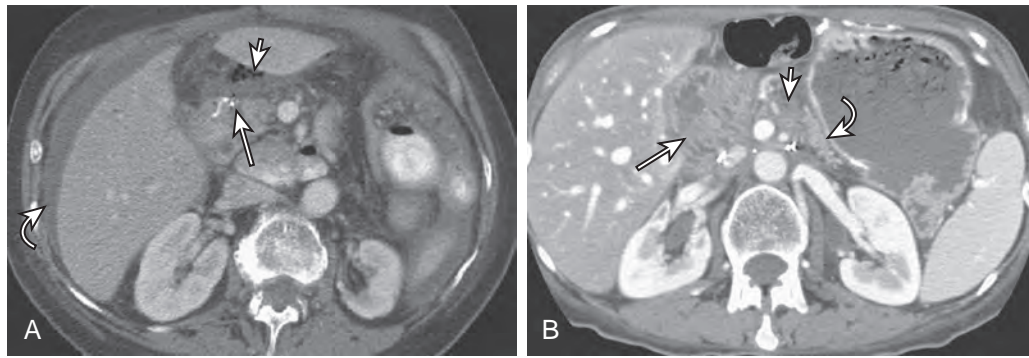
Follow-up imaging after Whipple procedure. A. Anastomotic breakdown. Contrast-enhanced CT in a 67-year-old woman on postoperative day 10 after Whipple procedure. There is dehiscence of the anastomosis at the afferent loop (*long arrow*) with a small collection of air (*short arrow*) and early abscess formation. Perihepatic free fluid is also present (*curved arrow*). B. Recurrent pancreatic cancer. Contrast-enhanced CT in a 57-year-old woman 8 months after Whipple procedure for pancreatic cancer. There is a soft tissue mass encasing the mesenteric vasculature (*short arrow*). The afferent loop (*long arrow*) has a normal appearance. Expected pancreatic body and tail atrophy is seen (*curved arrow*).
